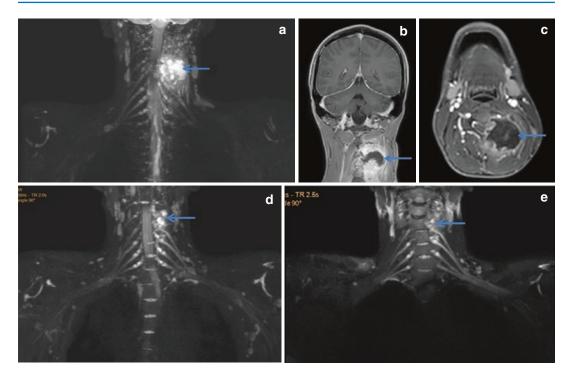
A 35-year-old man presented with left-sided root pain. Coronal fat-suppressed T2-weighted image (a) shows large T2 hyperintense area around left fourth and fifth spinal nerve root and trunk. Coronal (b) and axial (c) post-contrast T1-weighted fat-suppressed images show rim-enhancing cervical abscess in the corresponding
